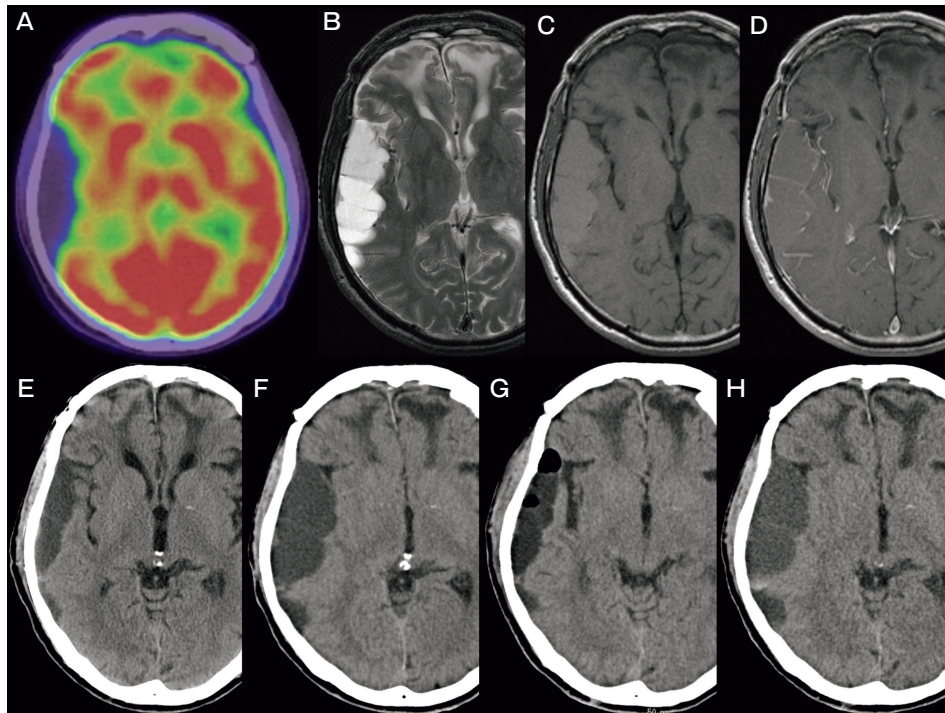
Radiological findings after the first surgery, chemotherapy, and radiotherapy. A, FDG-PET performed 6 years after the first treatment showing an intracranial lesion without FDG accumulation; B, T2-weighted MRI showing an intracranial extra-axial lesion with high signal intensity; C, T1-weighted MRI showing an intracranial extra-axial lesion with slightly high signal intensity compared with cerebrospinal fluid; D, Gadolinium-enhanced T1-weighted MRI showing no apparent enhancement in the lesion except in the cerebral veins; E, CT performed 2 weeks after the first drainage surgery showing shrinkage of the lesion; F, CT performed 8 months after the first drainage surgery showing regrowth of the lesion; G, CT performed 3 days after the second drainage surgery showing shrinkage of the lesion; H, CT performed 2 weeks after the second drainage surgery showing regrowth of the lesion.
